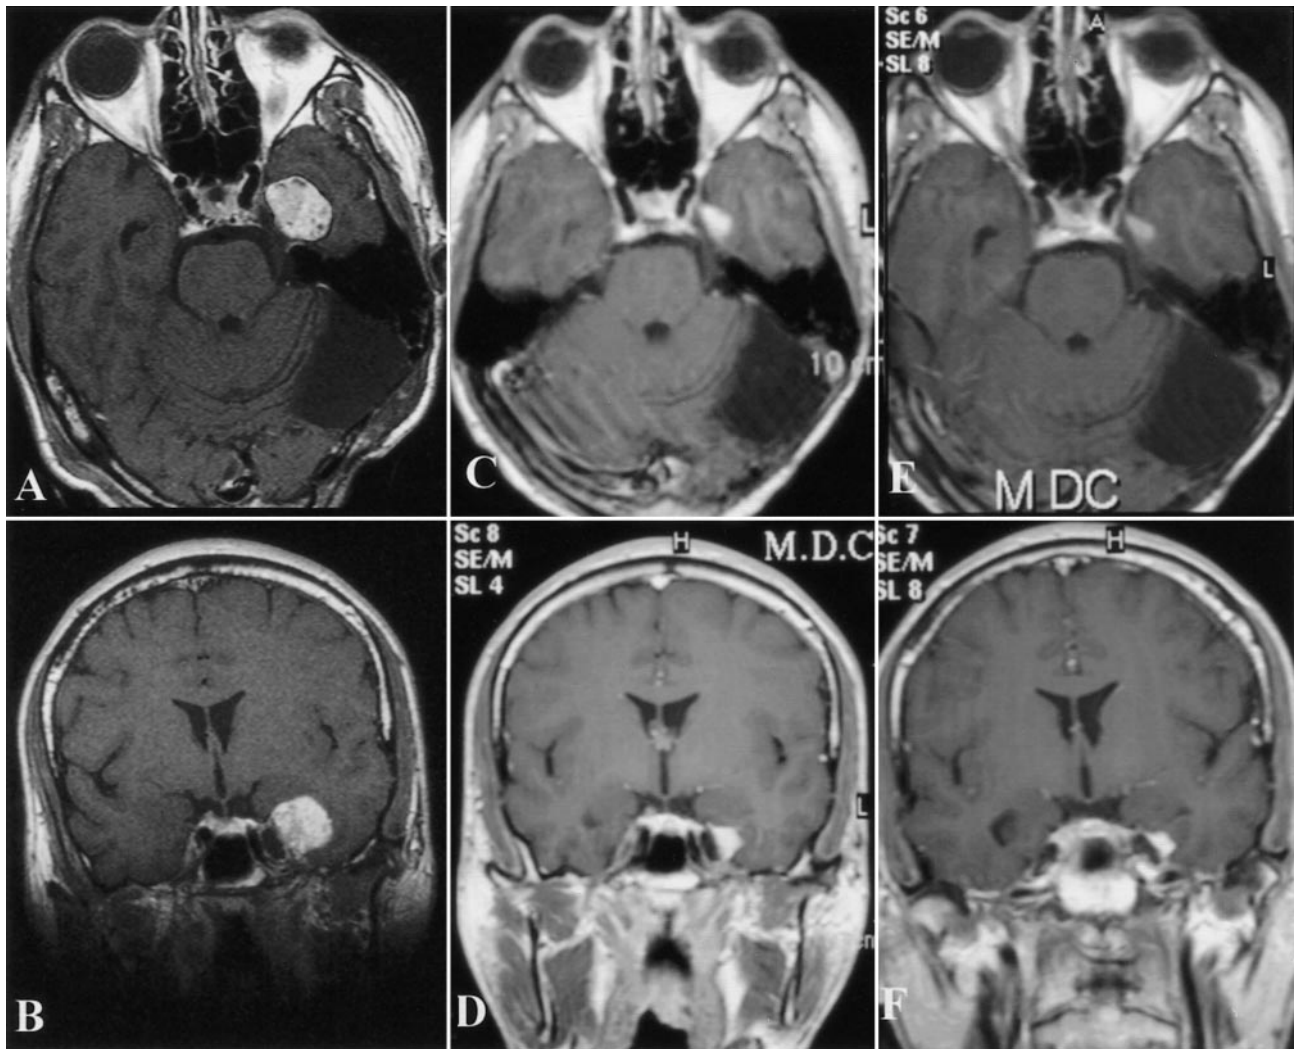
A 31 year old man with a left medial temporal lobe hemangiopericytoma as shown on the treatment post contrast axial (A) and coronal (B) MRI. Five months later the tumor is 50% smaller as shown on axial (C) and coronal (D) images. One year after Gamma surgery the tumor had continued to regress as shown on axial (E) and coronal (F) scans. (Patient 8, Table 1.)
